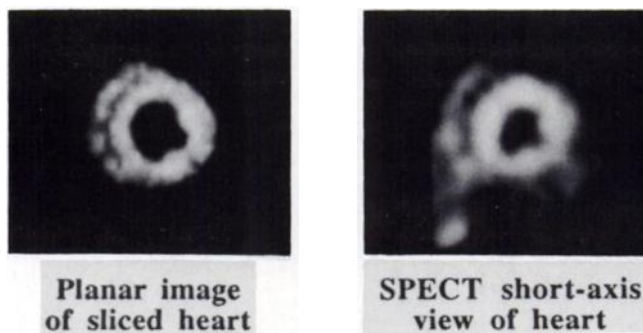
A short-axis view SPECT image and a planar image of the sliced heart.
